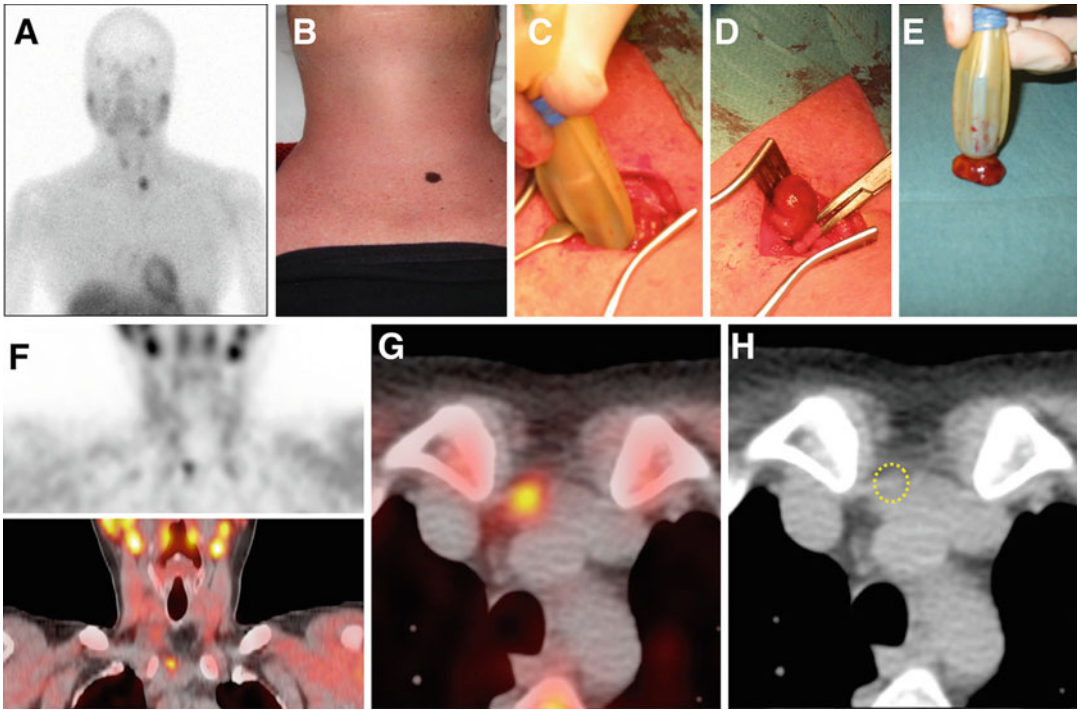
Planar scintigraphy (a) showing increased ^{99m}Tc -sestamibi uptake near the *left lower pole* of the thyroid. Following skin marking (b), a parathyroid adenoma is intraoperatively localized and resected using a handheld probe
